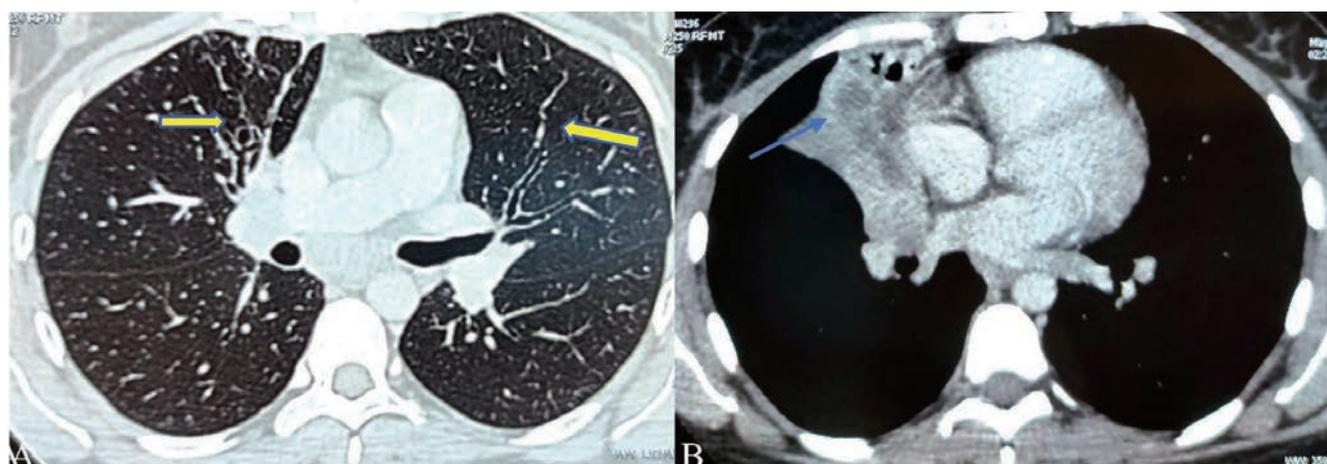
Patient's CT chest showing (A) central bronchiectasis (yellow arrows) and (B) middle lobe atelectasis (blue arrow).
